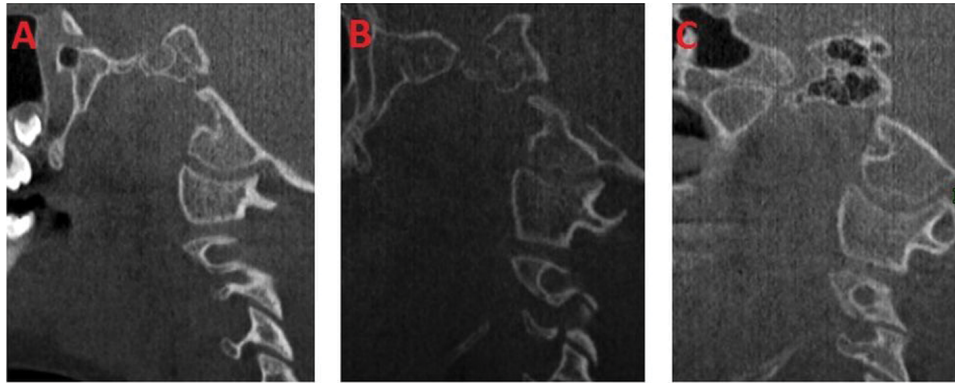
Sagittal cone beam computed tomography images; A. Absence of ponticulus posticus; B. Partial ponticulus posticus; C. Complete ponticulus posticus.
